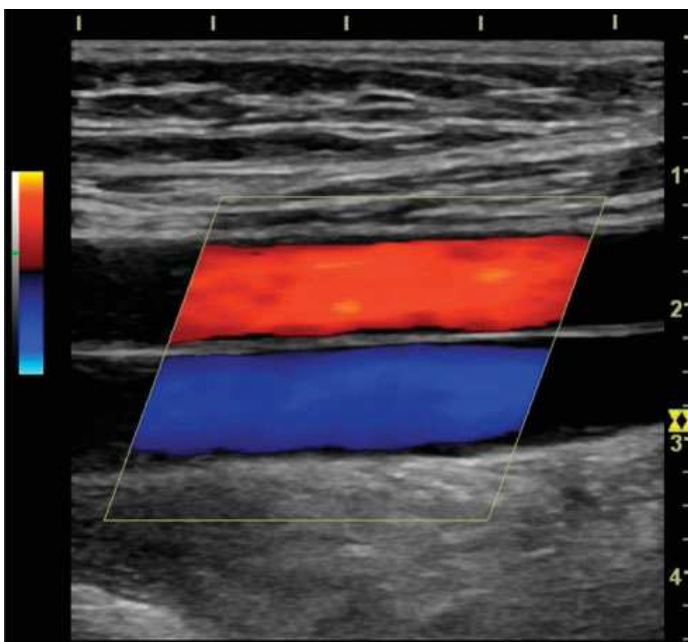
Colour Doppler image showing a colour Doppler map of mean velocity for the two blood vessels imaged in figure 3.1.
